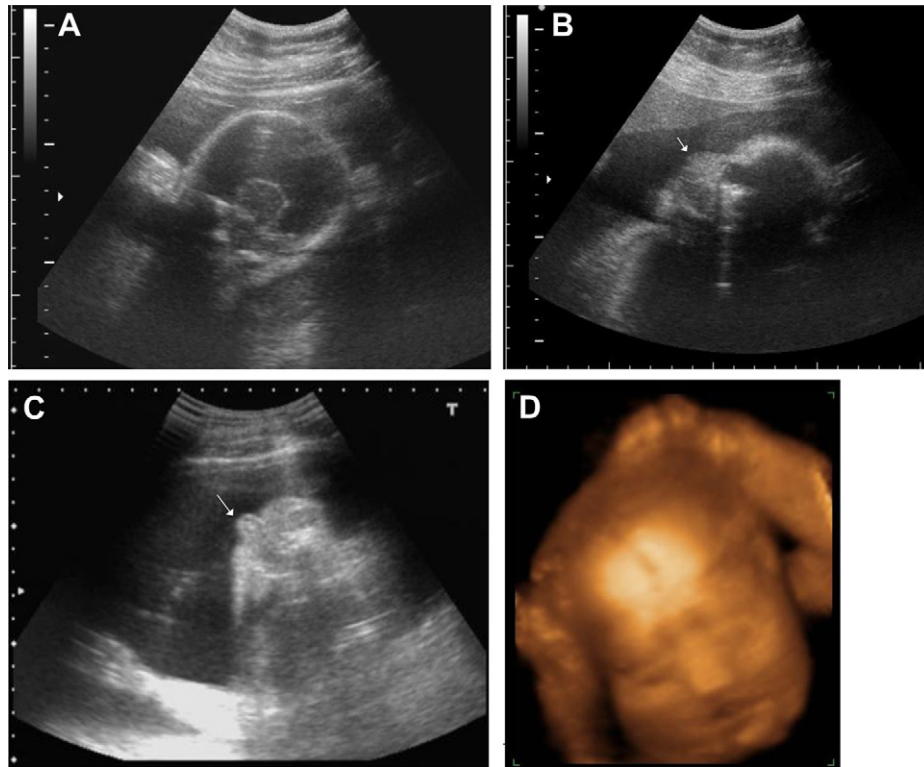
Prenatal ultrasound at 24 weeks of gestation shows (A) alobar holoprosencephaly with a fused thalamus and a single ventricle; (B) a prominent nose (arrow); (C) micropenis (arrow); and (D) ceboccephaly and hypotelorism on three-dimensional ultrasound.
